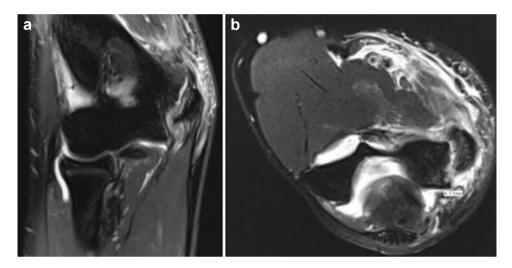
Coronal (a) and axial (b) MRI views to show displaced medial epicondyle fracture.
